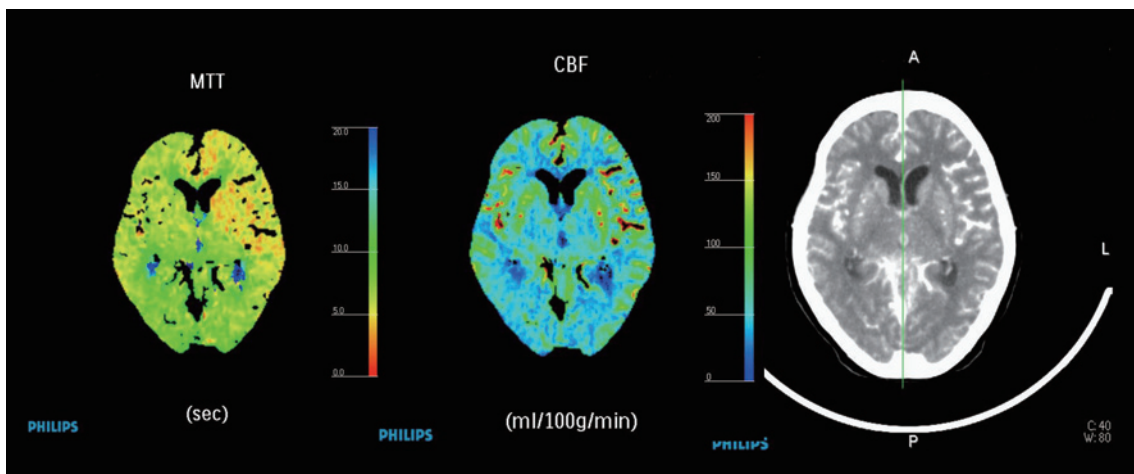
Case5. Perfusion computed tomography performed 2 hours after rupture of a basilar artery top aneurysm. [left, mean transit time (MTT); middle, cerebral blood flow (CBF); right, plain CT image]. The CBF is reduced and MTT is significantly extended bilaterally in the temporal and thalamic regions. Because basilar artery top aneurysm was in the center of the brain, hemodynamic disturbances affect both hemispheres.
